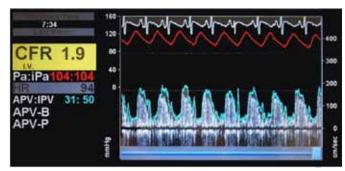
Intracoronary Doppler blood flow velocity waveforms in response to intracoronary adenosine. Coronary flow reserve is the ratio of average peak velocities before and after adenosine administration. Adenosine tests nonendothelial-dependent microvascular function.
